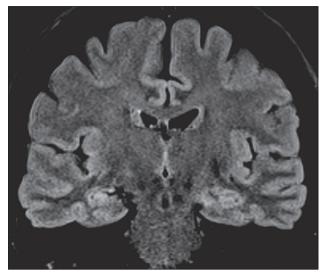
MRI brain T2 FLAIR image reveals decreased hippocampal volume and hyperintensity on the right side suggestive of right hippocampal sclerosis (age 47).
